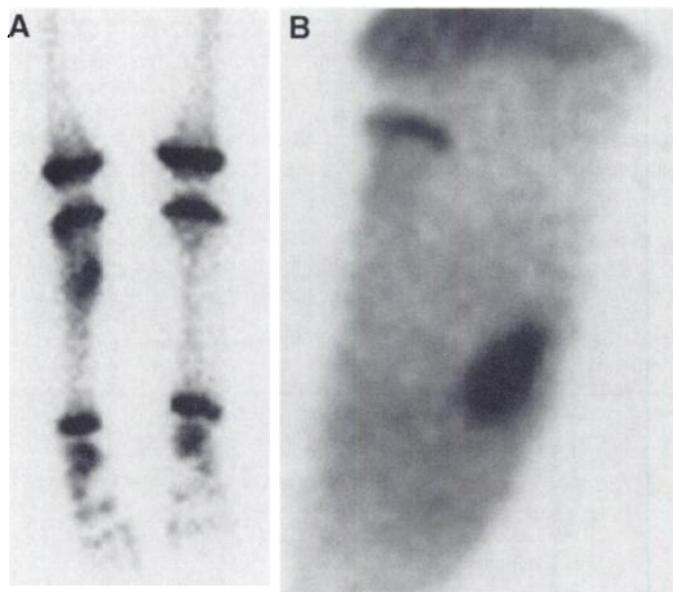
Osteoid osteoma. (A) Skeletal scintigraphy of a 4-yr-old boy shows intense tracer localization in the right tibial diaphysis medially. (B) Pinhole imaging (lateral projection) shows a well-defined focus of intense tracer localization in the tibia anteriorly with an adjacent zone of slightly increased localization.
